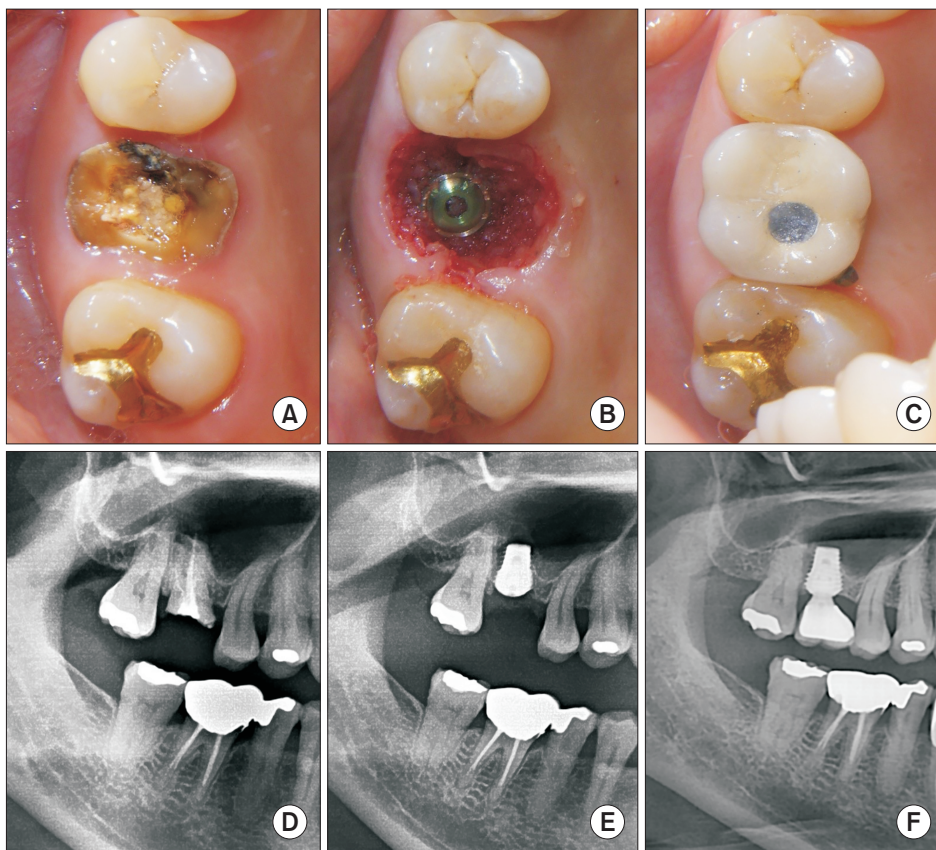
Clinical photographs and panoramic radiographs demonstrating the clinical progress of Patient 6. A. Preoperative clinical photograph. B. Intraoperative clinical photograph showing immediate implant placement with bone grafting. C. Clinical photograph after final restoration. D. Preoperative panoramic radiograph. E. Immediate postoperative panoramic radiograph. F. Panoramic radiograph taken 101 months after final restoration.
